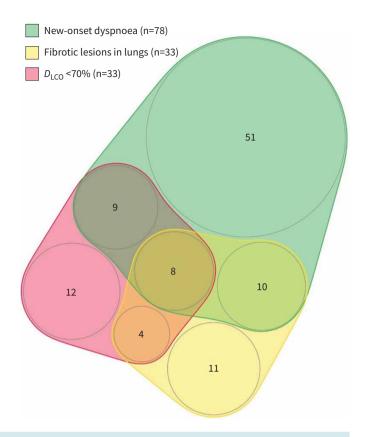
Distribution of patients evaluated at ambulatory care visits according to new-onset dyspnoea, fibrotic lung lesions on high-resolution computed tomography and decreased D_{LCO} <70%. D_{LCO} : diffusing capacity of the lung for carbon monoxide.
